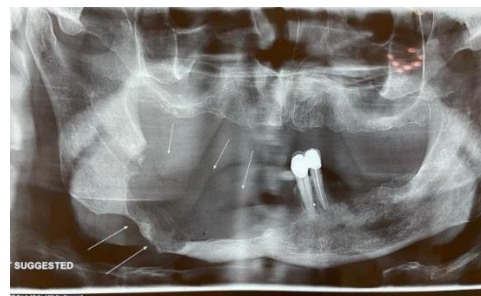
Panoramic radiograph of a 65-year-old male showing bilateral, poorly defined punched-out radiolucent lesions in the mandibular body.
